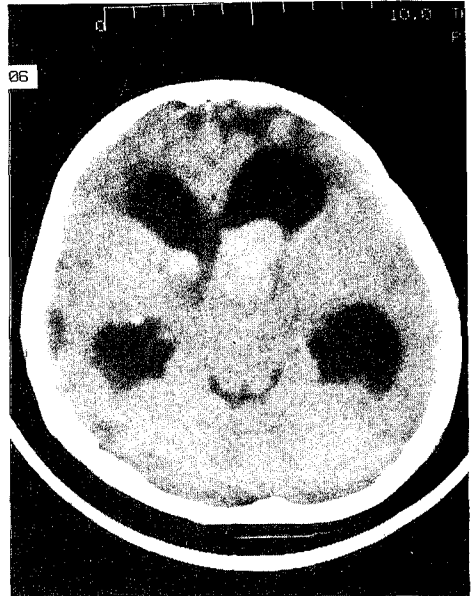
CT scan of brain at the age of 6 years showing a moderate-enhanced tumor in the left frontal horn with extension into bil. foramina of Monro.
